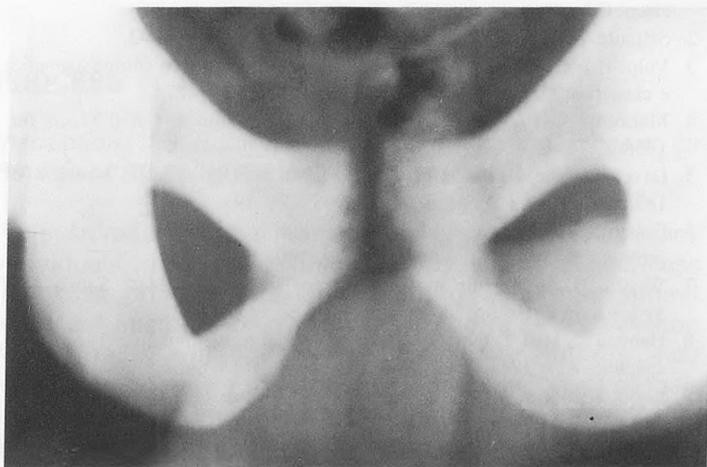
Radiograph of the symphysis pubis demonstrating increased space between the symphysis.
